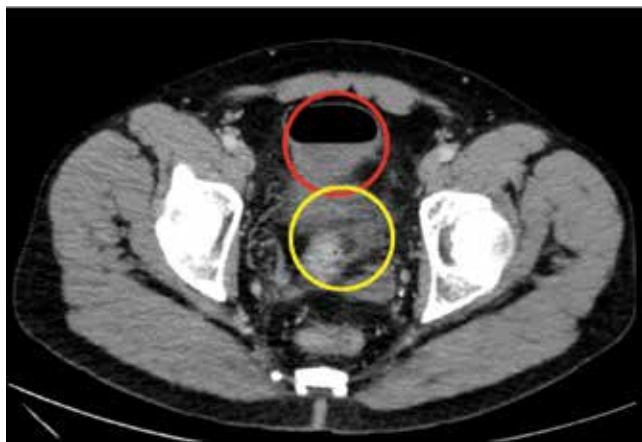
CT scan suggesting a colovesical fistula with air in the bladder (red circle) and an adjacent segment of thickened sigmoid colon (yellow circle).
